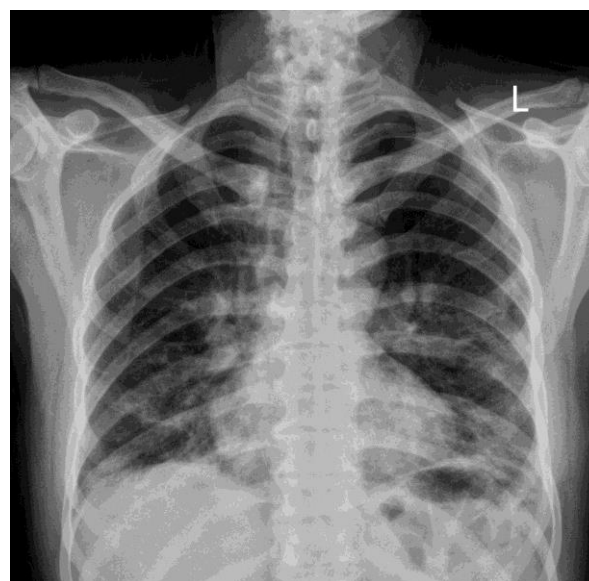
Chest X-ray of the patient; presence of patchy infiltrates of both lungs, particularly in the lower fields
